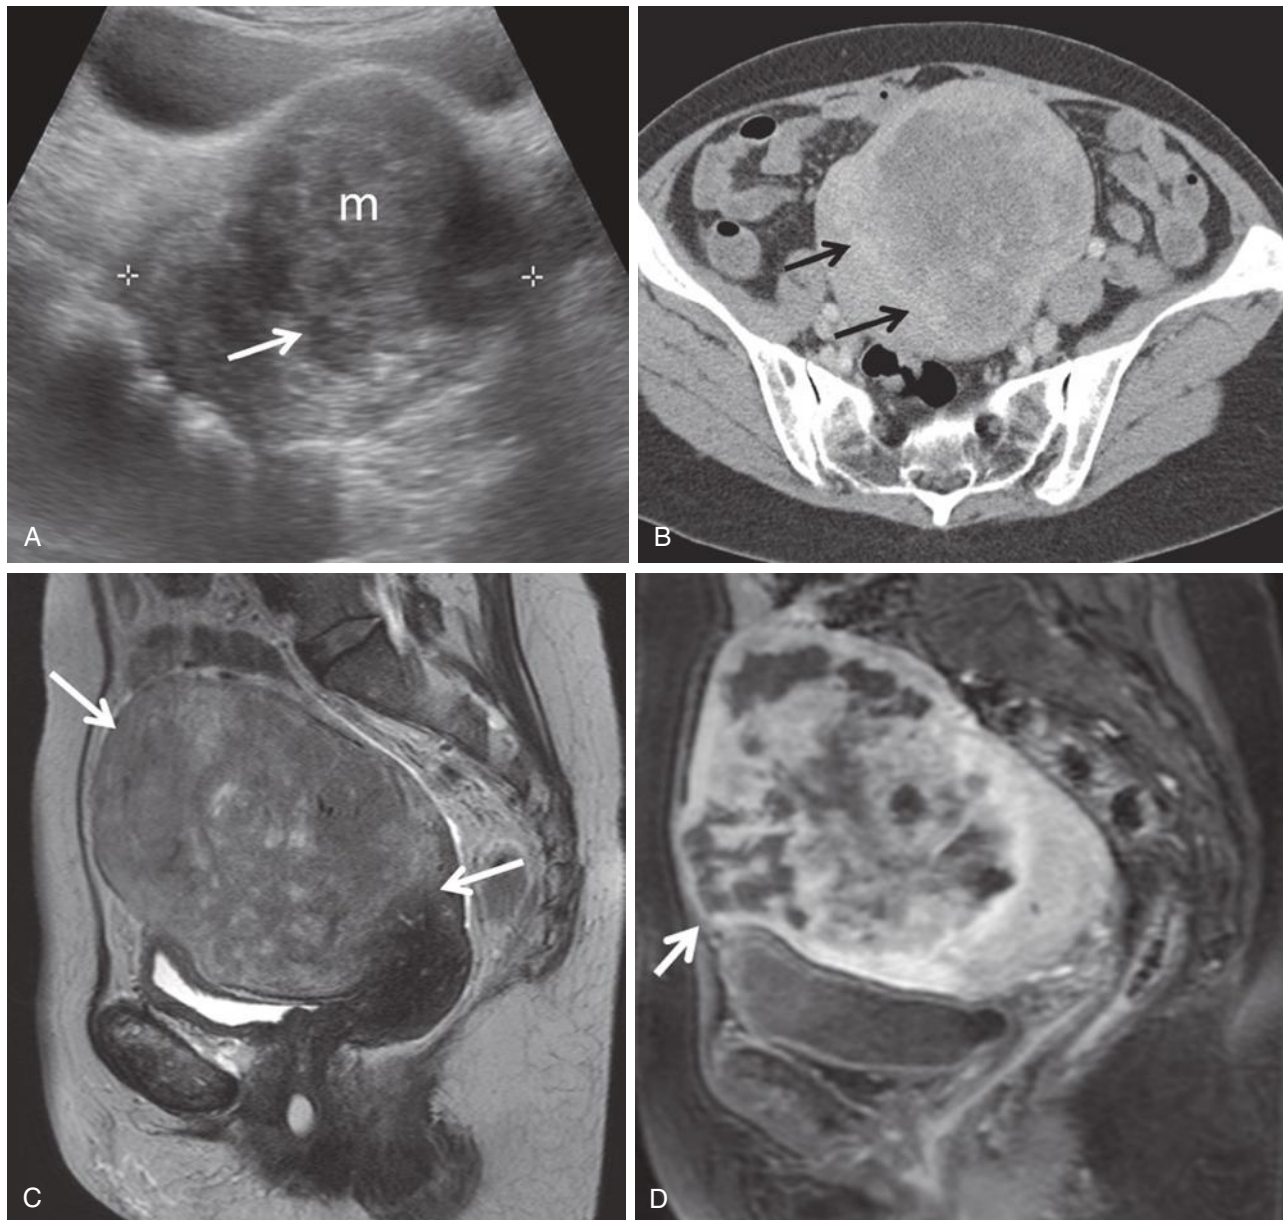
Leiomyosarcoma in postmenopausal patient with pelvic pain and enlarging pelvic mass. A, Transabdominal ultrasound image demonstrates large partially exophytic mass (m) arising from the uterus (calipers). The margins of the mass (arrow) appear irregular. B, Contrast-enhanced axial computed tomography scan demonstrates infiltrative margins of the mass (arrows) along the border with adjacent myometrium. C, T2-weighted sagittal magnetic resonance (MR) image demonstrates heterogeneous increased signal within the large uterine mass (arrows). The margins of the lesion with adjacent myometrium are indistinct and difficult to appreciate, suggesting the infiltrative nature of the mass. D, Postcontrast sagittal T1-weighted fat-suppressed MR image demonstrates heterogeneous enhancement of the mass with areas of necrosis, irregular borders, and infiltration of the ventral abdominal wall (arrow).
